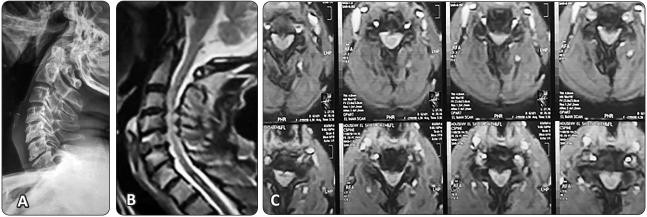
An 59-year-old man suffered from multi level cervical discs c3/4, c4/5, c5/6, c6/7, he also complained of hypertrophied ligamentum flavum. (A,B,C) Preoperative x ray and MRI demonstrated that the cord is pinched at c3/4 and c4/5. The patient underwent multilevel posterior laminectomies and lateral mass fusion C3-C6. (D) Postoperative lateral X-ray showing satisfactory laminectomies and screws. The patient improved clinical on JOA from 12 to 13 and Nurick DI stationary at 4.
